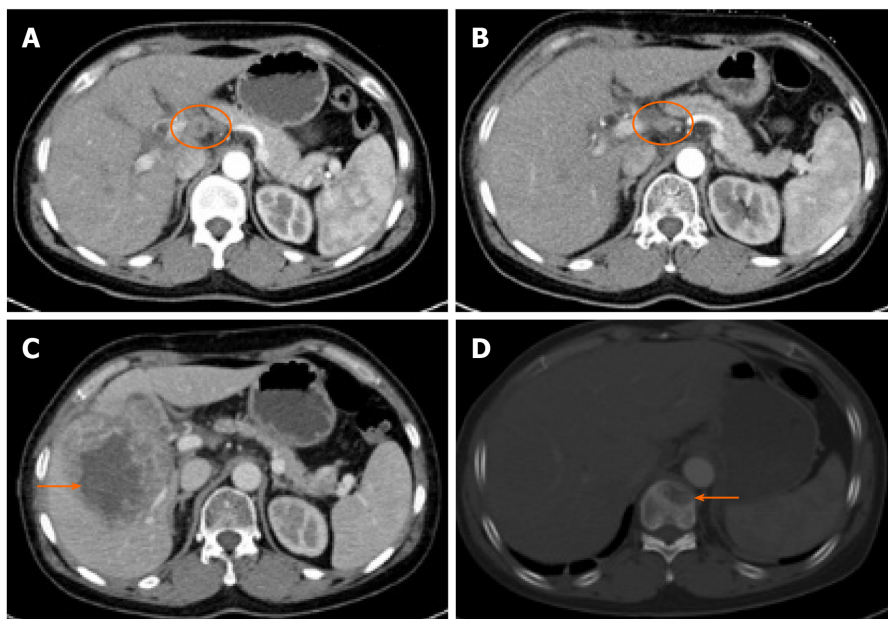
Computed tomography images. A: Lymph node involvement before adjuvant therapy; B: Computed tomography image showing a significant reduction in lymph node involvement (B circle) compared to that before adjuvant therapy (A circle); C: Metastases in the liver (arrow); D: Metastases in the thoracic vertebra (arrow).
